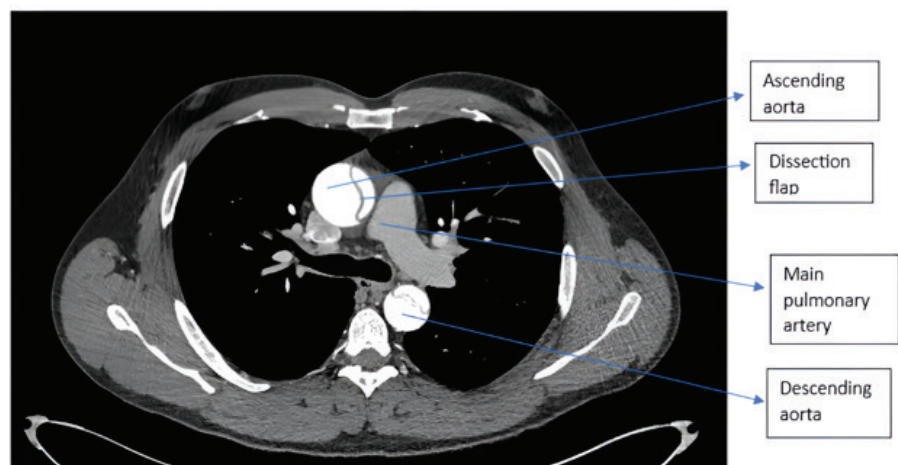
Chest computed tomography scan showing Type A acute aortic dissection.
